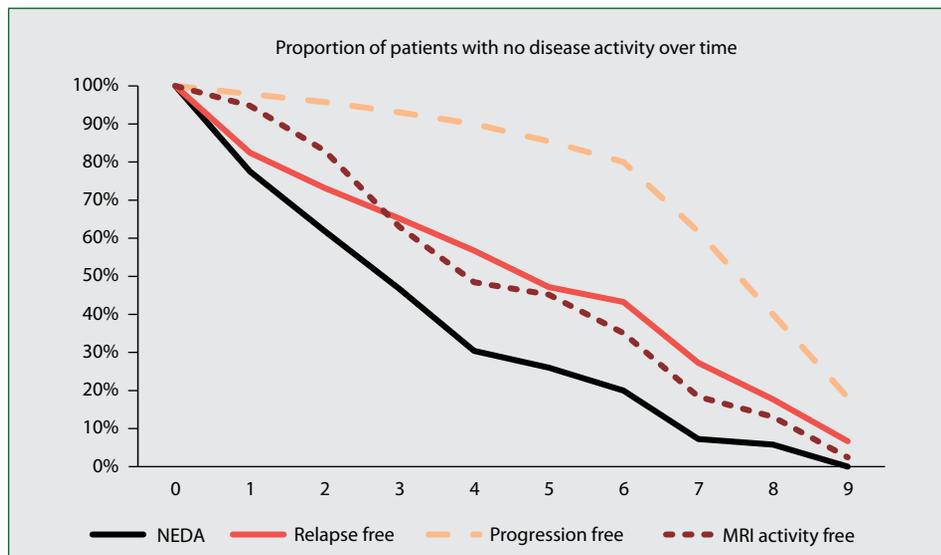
Proportion of patients with no disease activity (according to NEDA-3 criteria), relapses, progression and MRI activity over time
